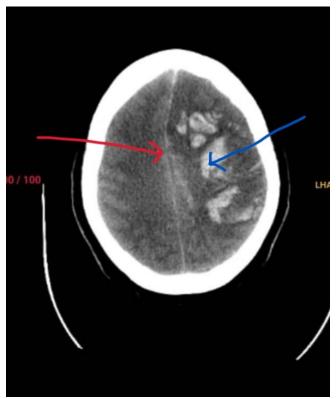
CT brain scan indicating the intracerebral haemorrhage (blue arrow) and the midline shift (red arrow)
